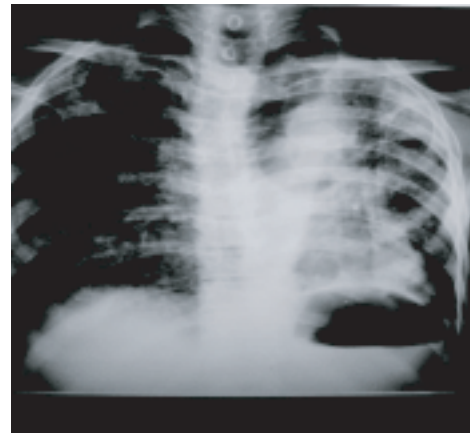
Chest radiograph shows Koch's Lesion
